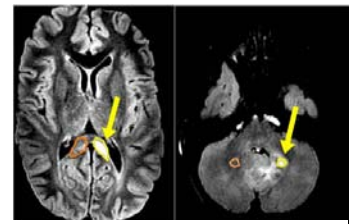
UBO (yellow) and contralateral NAWM (orange) on T2-weighted image
